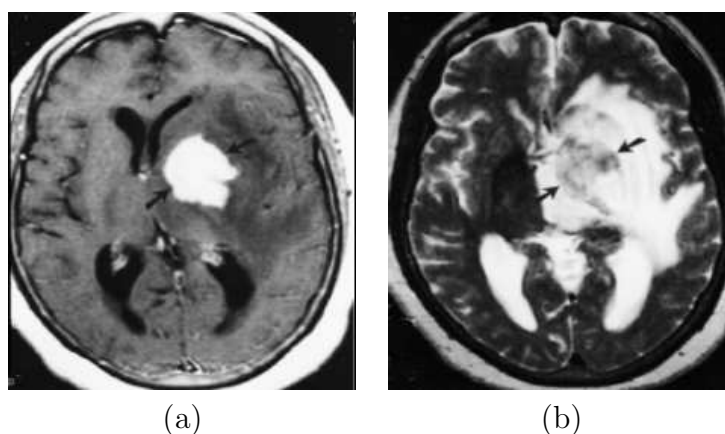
High grade oligodendroglioma. a) Contrast enhanced T1-weighted image. b) T2-weighted image from the same patient, showing isointense to hyperintense appearance of the mass [Engelhard et al., 2003].
